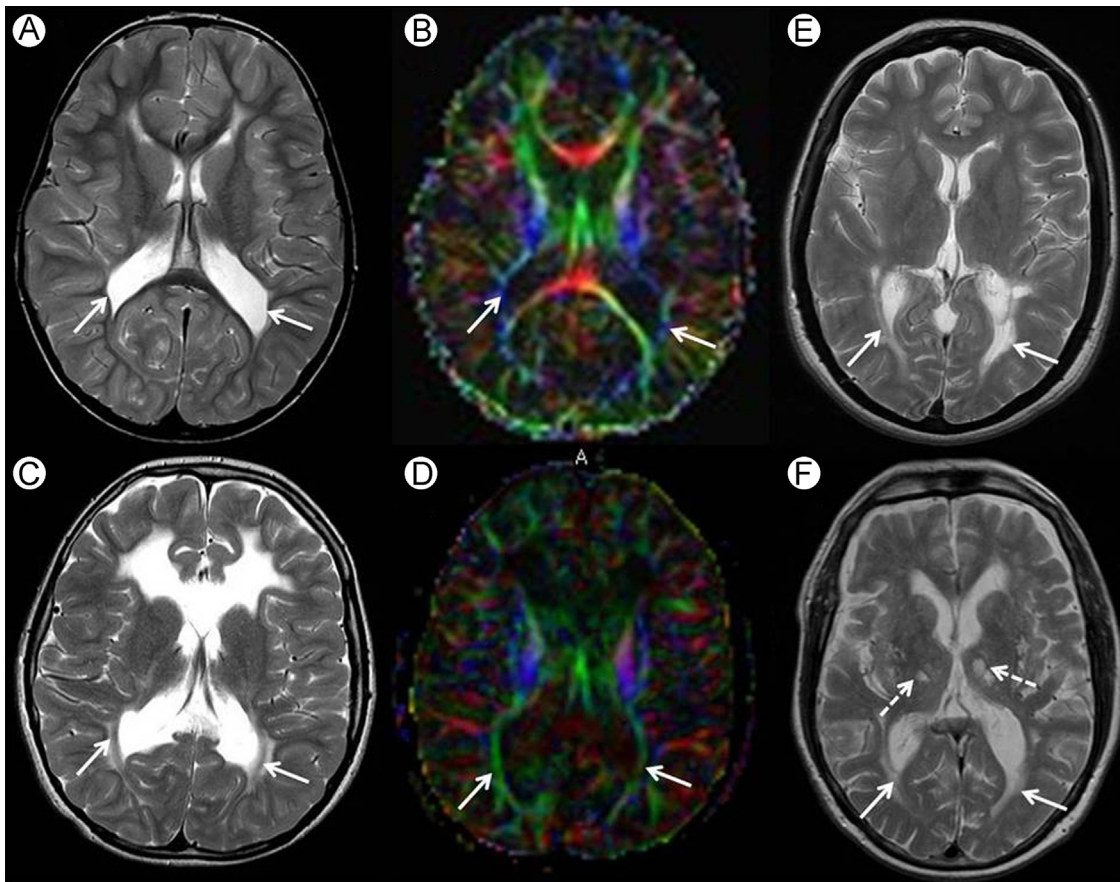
White matter disease affecting the optic radiations. (A) Axial T2 and (B) color FA map in a child with extensive PVL. There is severe loss of periventricular white matter and corresponding loss of visualization of the optic radiations on DTI (arrows, A and B). (C) Axial T2 and (D) color FA map in a second child with frontal variant of adrenoleukodystrophy shows relative preservation of optic radiations (arrows, C and D) compared with extensive destruction and lack of visualization of normal frontal white matter (images A-D courtesy of Dr T Jaspan, NUH, UK). (E) Axial T2-weighted image of a patient with multiple sclerosis with diffuse periventricular disease affecting the optic radiations (arrows). (F) Axial T2-weighted image of an elderly patient with extensive small vessel ischemic change shows T2 hyperintensity involving the optic radiations (arrows) and mature lacunar infarcts in the thalami (dashed arrows). FA, fractional anisotropy; PVL, periventricular leukomalacia.
